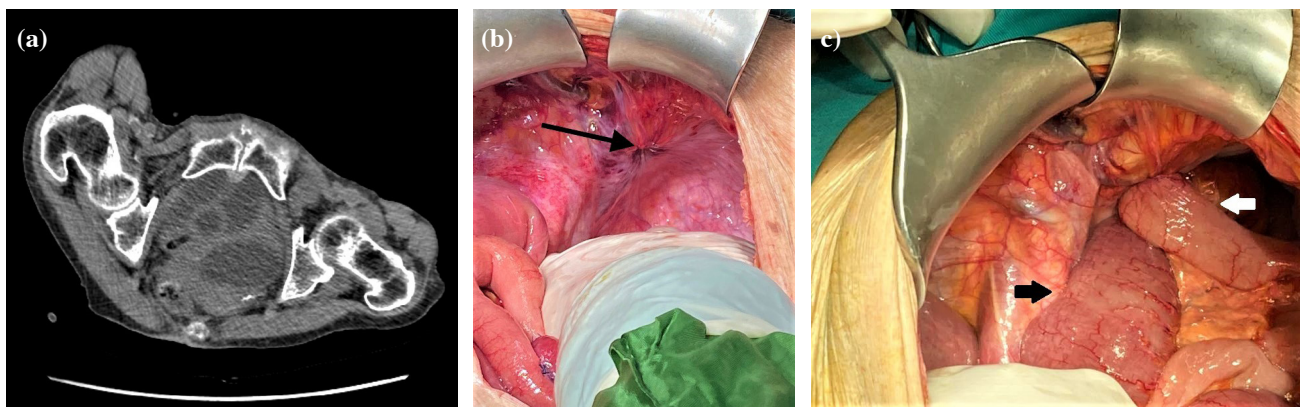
(a) A radiologic image; transverse view, demonstrating a left-sided obstructive obturator hernia, Case N.1 (Computed tomography scan; Axial view). (b) A radiologic image; transverse view, demonstrating a left-sided obstructive obturator hernia, Case N.1 (Computed tomography scan; Transverse view).
